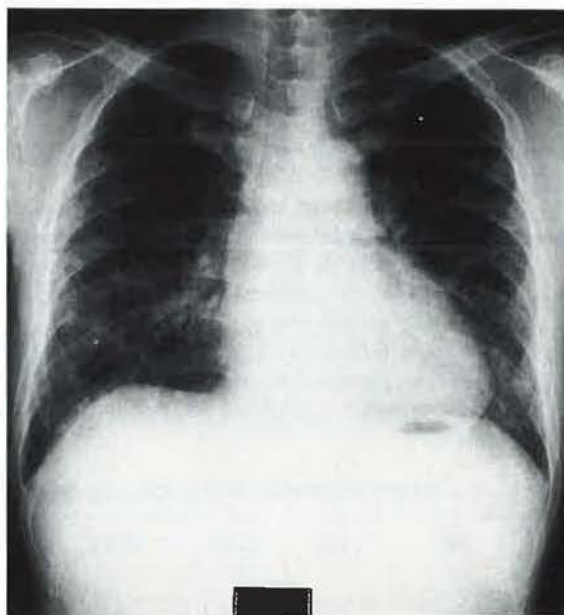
Chest radiograph on admission showing a diffuse reticulonodular infiltrate in both lungs.
